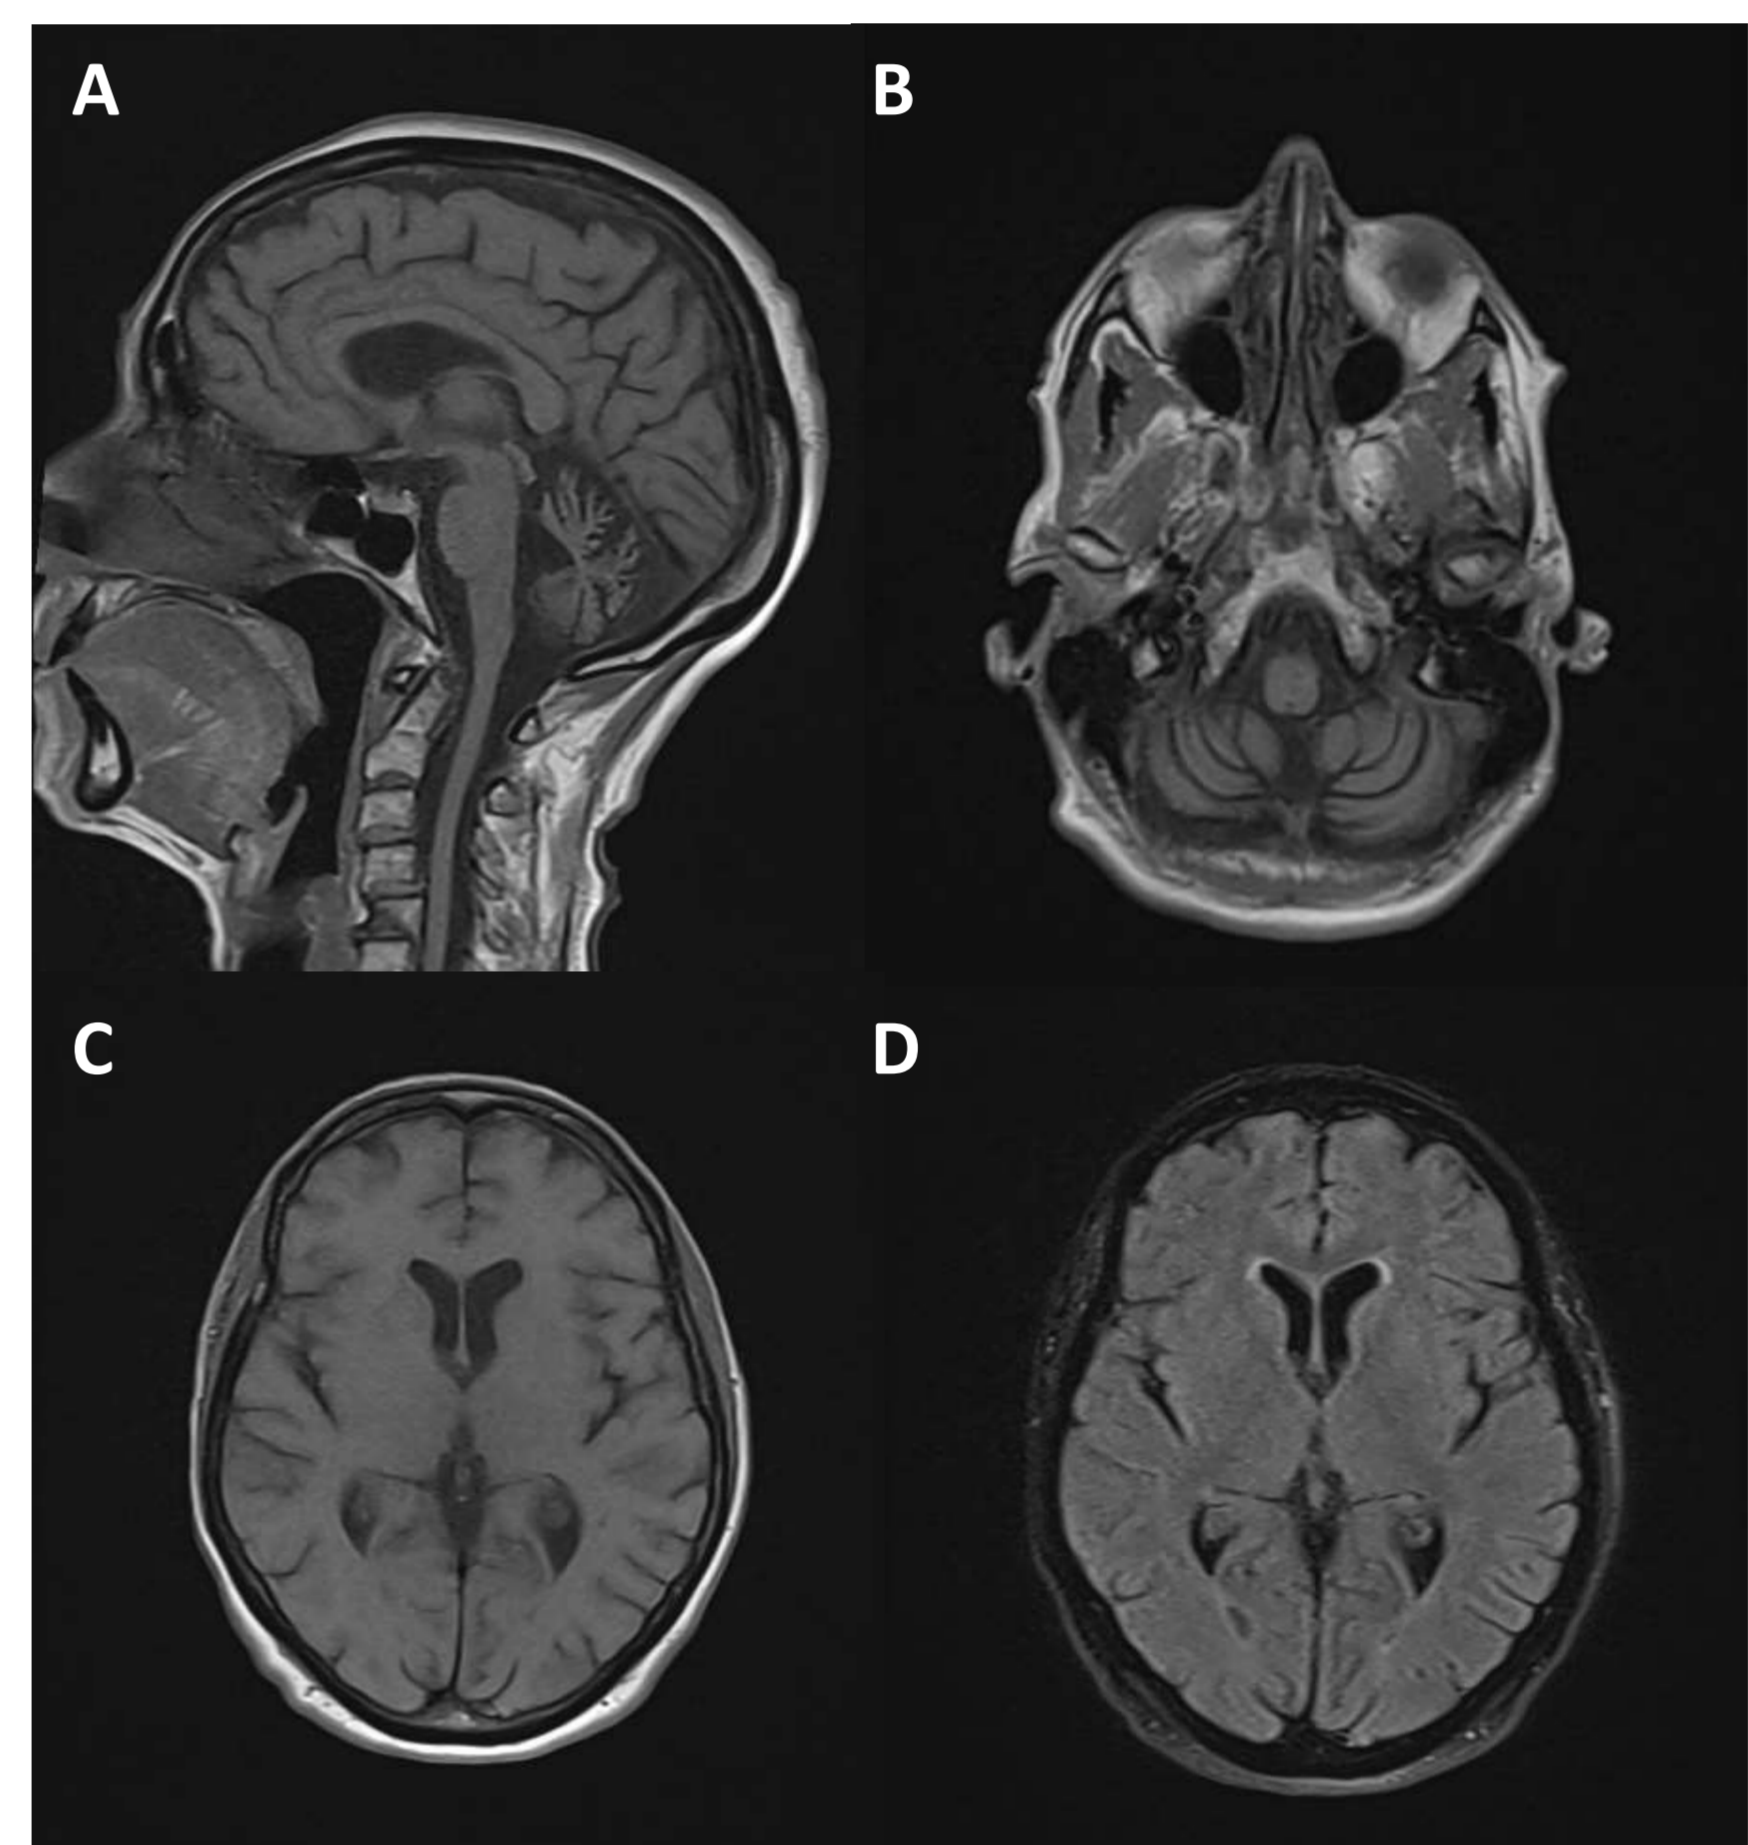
MRI findings. Sagittal (A) and axial (B) MRI sequences revealed subtentorial cerebellar atrophy, more prominent in the vermis, without associated brainstem involvement. Axial MRI sequences of the supratentorial region at T1 (C) and FLAIR (D) did not show frontal horn abnormalities, consistent with absence of the "ears of the lynx" sign
